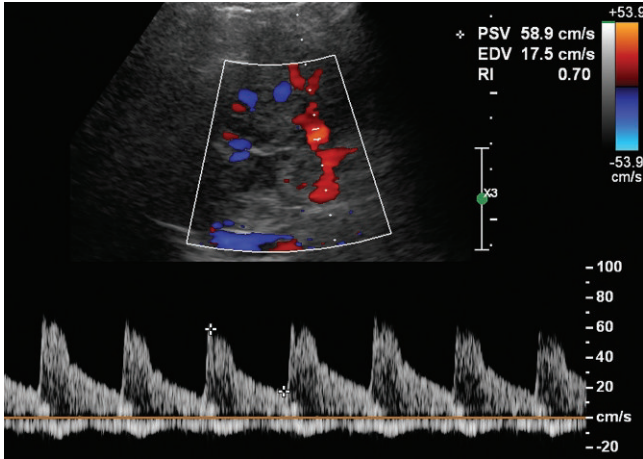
Doppler of the portal vein and hepatic artery can be obtained by having a large enough sample volume size to record both vessels. In this case hepatofugal portal flow is confirmed by demonstrating the two vessels flowing in opposite directions. The reversed flow portal vein is below the baseline and the normal hepatic artery is above the baseline. In normal the two waveforms are superimposed.
